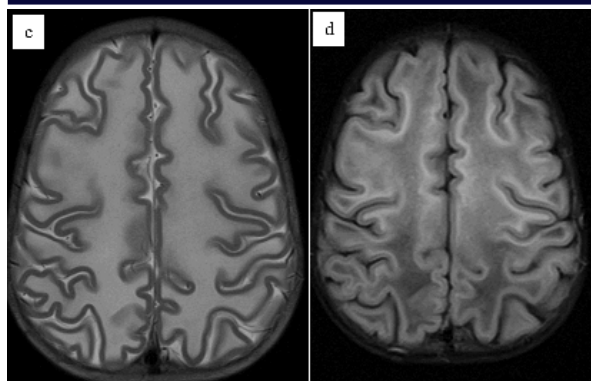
c) and d) T2W, FLAIR axial images diffuse white matter involvement in bilateral frontoparietal lobes.
